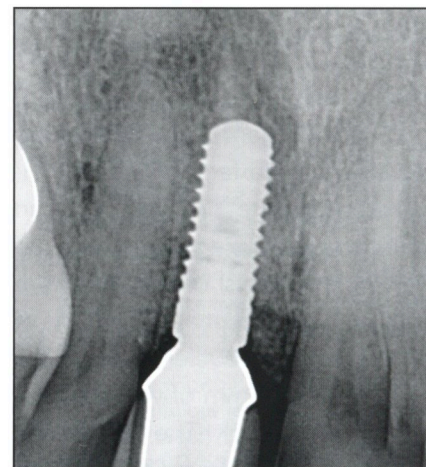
The final digital periapical radiograph 1 year postinsertion showed stable osseous healing.
